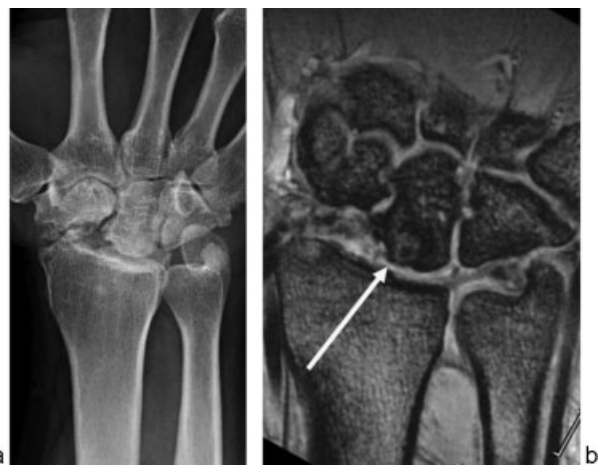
(a) PA X-ray image 21.3 months postoperative. This patient's degeneration was graded as mild. (b) Postoperative MRI at 21.3 months from surgery for the patient in ▶Fig. 7a reveals graft incorporation. Arrow indicates graft location.
